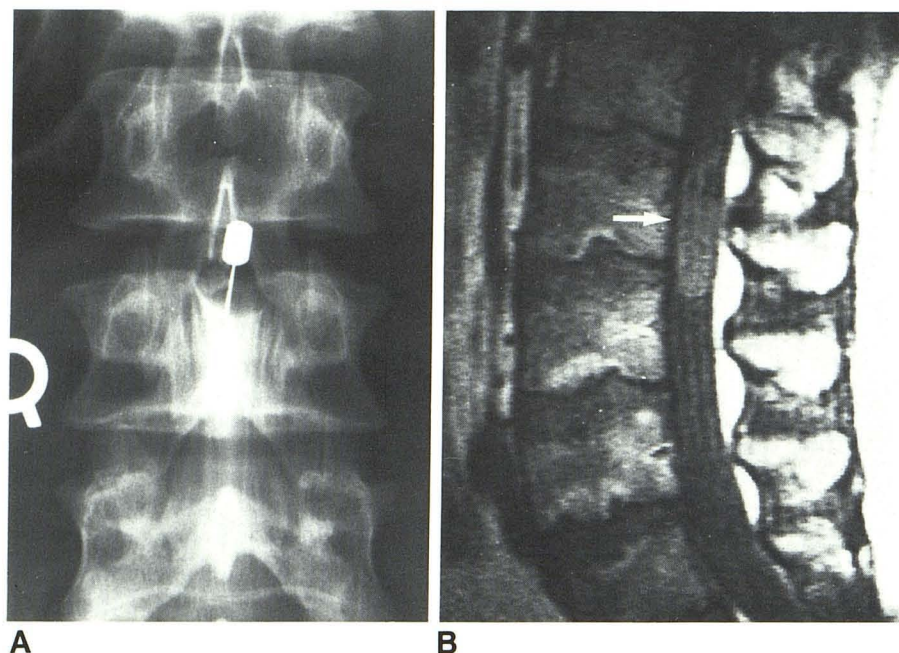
32-year-old man with L5 radiculopathy. A, Anteroposterior radiograph of lumbar spine at L3 level after installation of metrizamide into thecal sac. Note intradural filling defect at level of needle. CT without metrizamide performed before this study was normal to level of L3 pedicles. B, Sagittal 4-mm MR section (TE = 30 msec, TR = 0.5 sec) showed intradural mass of intermediate signal intensity at L2 and L2–L3 levels (arrow). An ependymoma was identified at surgery.
